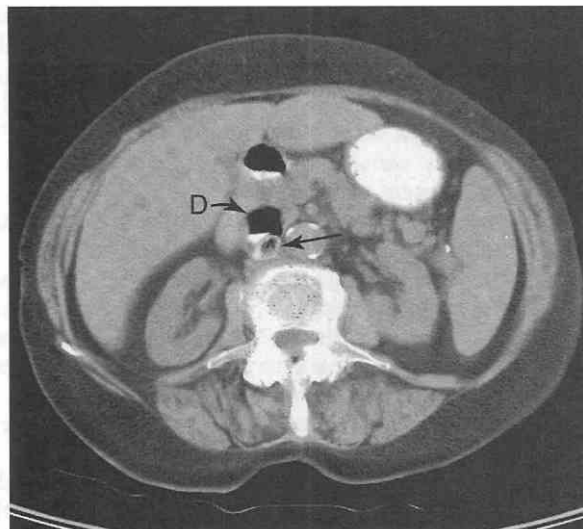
CT scan shows a large air collection with a contrast level in the cavity behind the head of the pancreas, anterior to the vena cava. Small amounts of air (arrow) are noted in the vena cava due to ulcer in diverticulum (D), which penetrated posteriorly.
